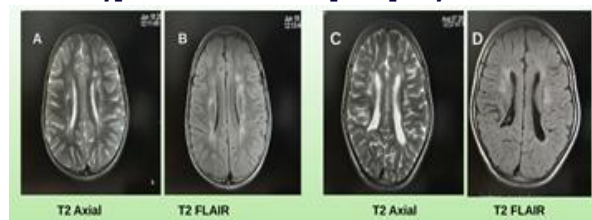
Two 8-year-old children, one male and one female. Images remain in the same A–B–C–D boxes as the PPT, preserving the T2 axial and T2 FLAIR pairs. T2/FLAIR hyperintensity is present in the bilateral periventricular white matter with mild dilatation of the lateral ventricles.
